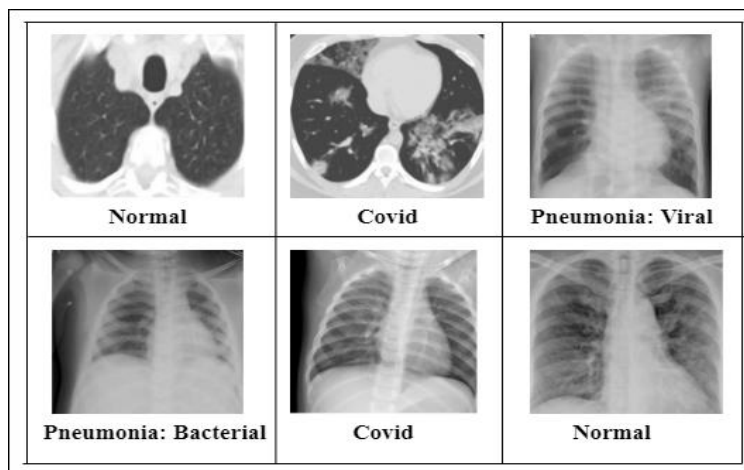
Sample CXR images and CT scans from the dataset.
